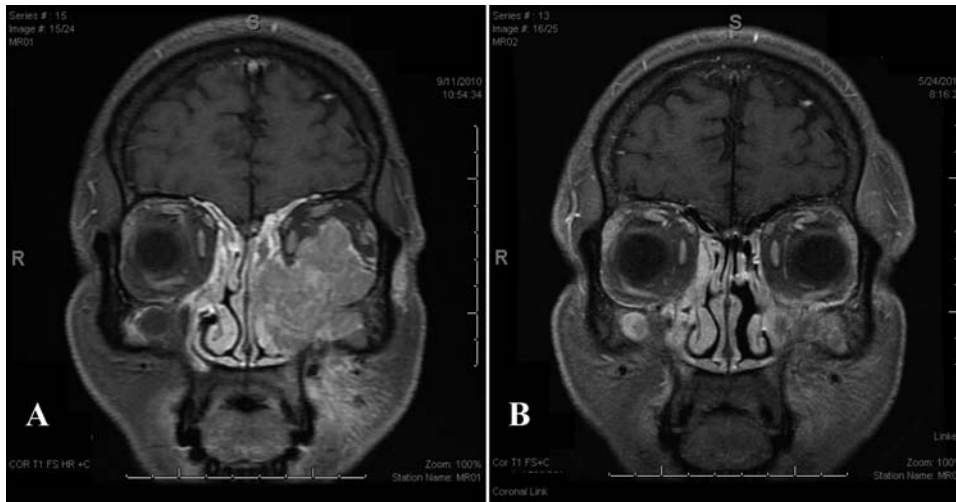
A, MRI scan of the brain and orbits coronal plane showing a solid enhancing mass measuring 4 cm × 4.5 cm × 3 cm filling the left maxillary sinus, abutting the optic nerve and eroding through the orbital floor into the left orbit, causing orbital globe and inferior rectus muscle displacement. B, MRI scan 4 months after completion of therapy.
